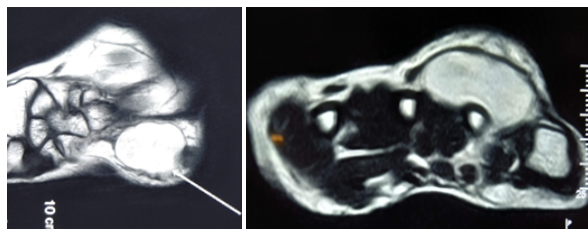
MRI showing a well defined T1 and T2 weighted homogenous hyperintense lesion seen involving the dorsal aspect of left hand adjacent to the 4th metacarpal bone elevating the adjacent extensor digitorum tendon
